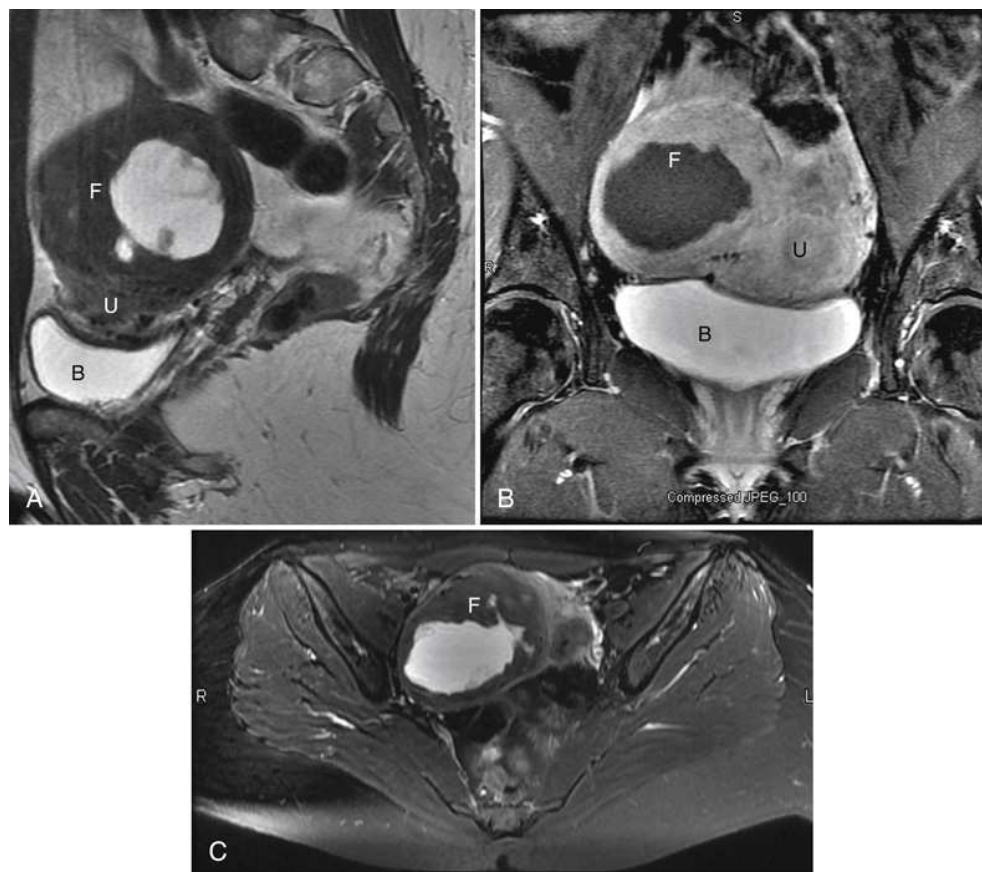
Multiple images through a female pelvis. (A) Sagittal T2-weighted image. (B) Coronal T1-weighted image after administration of contrast agent. (C) Axial T1-weighted image after administration of contrast agent with fat saturation. All images show the different components of a uterine fibroid (*F*). The relationship between the uterus (*U*) and bladder (*B*) is shown well using multiple imaging planes.
